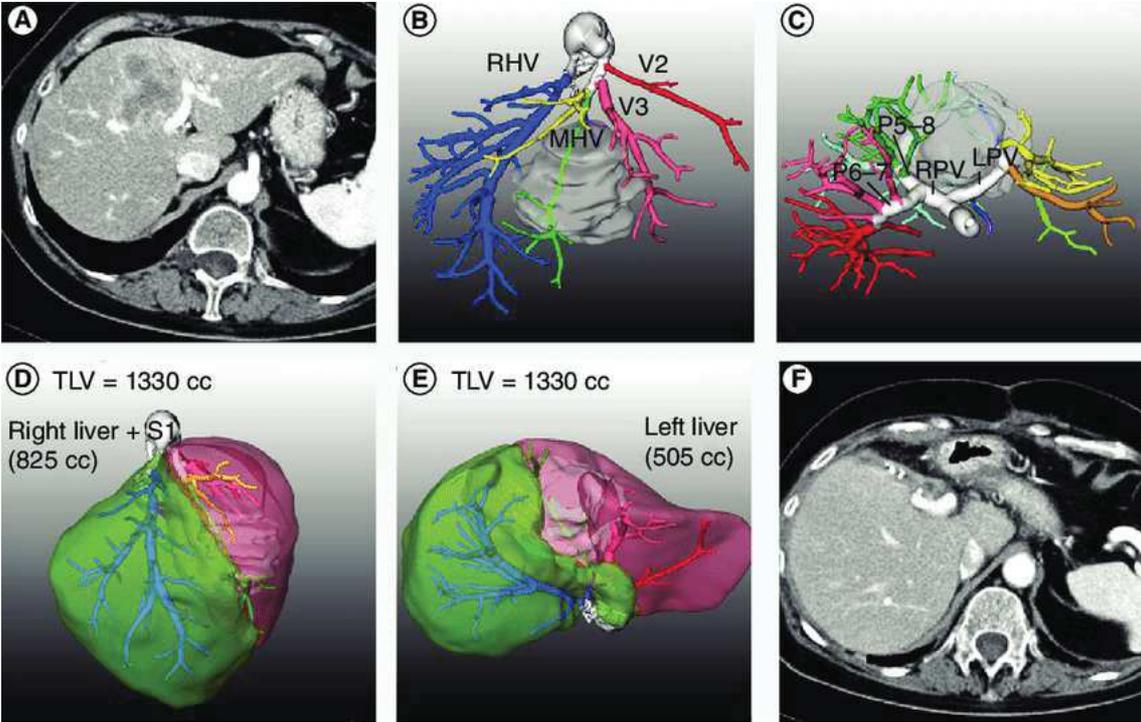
3D Liver Computed tomography
